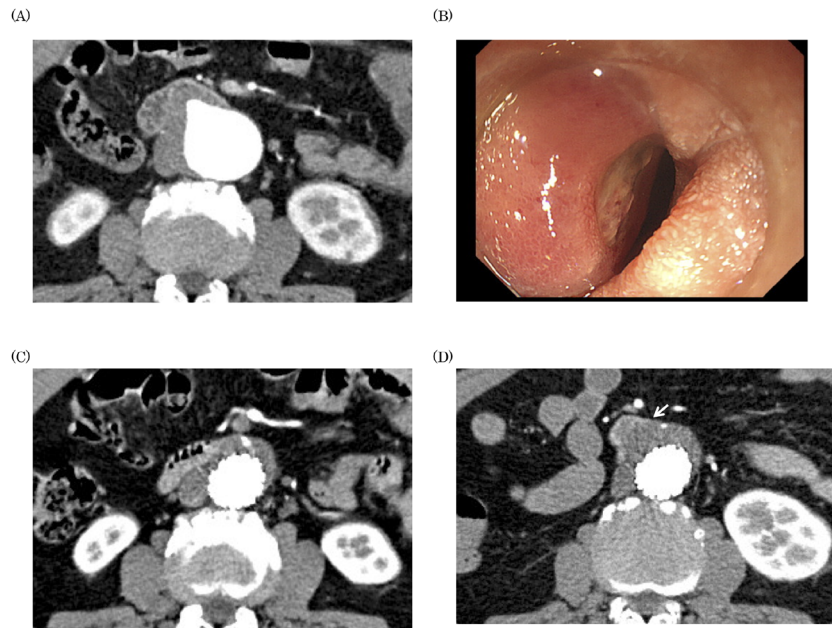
(A) Computed tomography (CT) image showing dilatation of the abdominal aortic aneurysm and a protrusion of the aortic wall facing the duodenum. (B) Upper gastrointestinal endoscopy showing a pulsatile mass and an ulcer in the third portion of the duodenum. (C) CT imagery from 2 years postoperatively, (D) CT imagery from 4 years postoperative showing a lack of continuity in the duodenal wall facing the aortic aneurysm (arrow).
